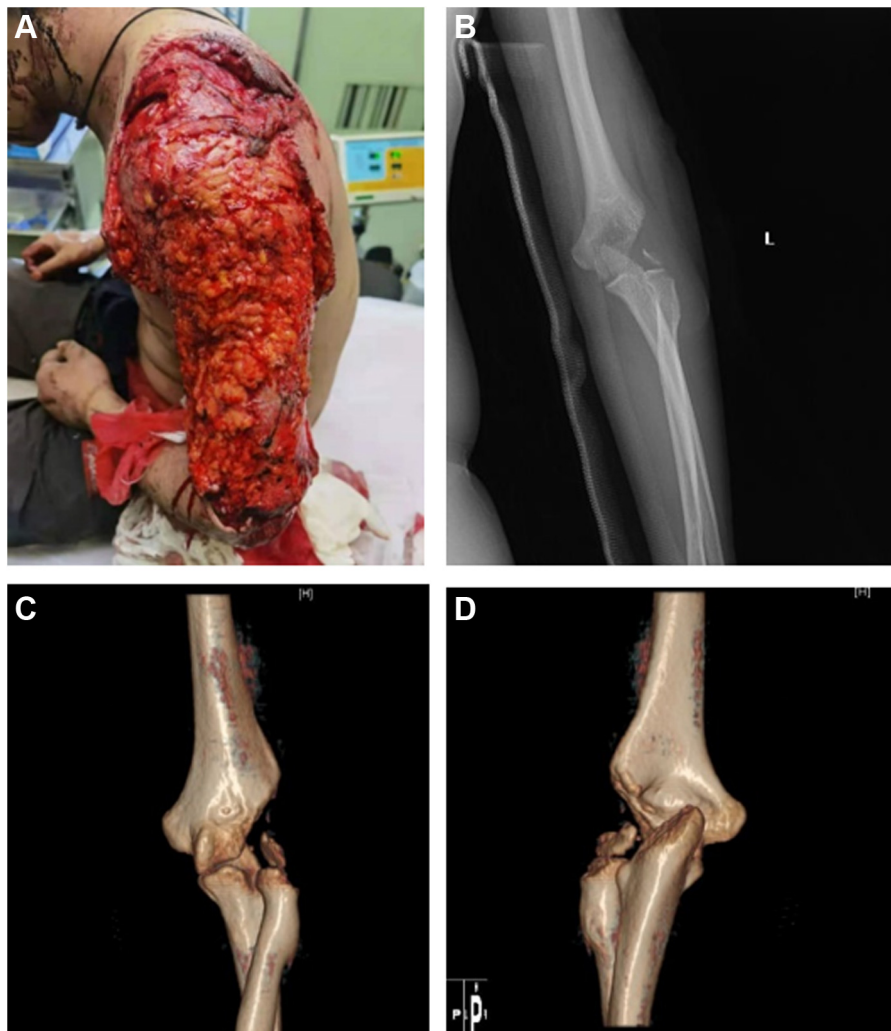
Images of a 20-year-old man who suffered an extensive avulsion injury and a large bone defect in the distal humerus. (A) An extensive avulsion injury from his upper left arm to his shoulder. (B) X-ray showed a large bone defect in the distal humerus. (C, D) Three-dimensional computed tomography showed a radial head fracture and a large bone defect in the distal humerus.
